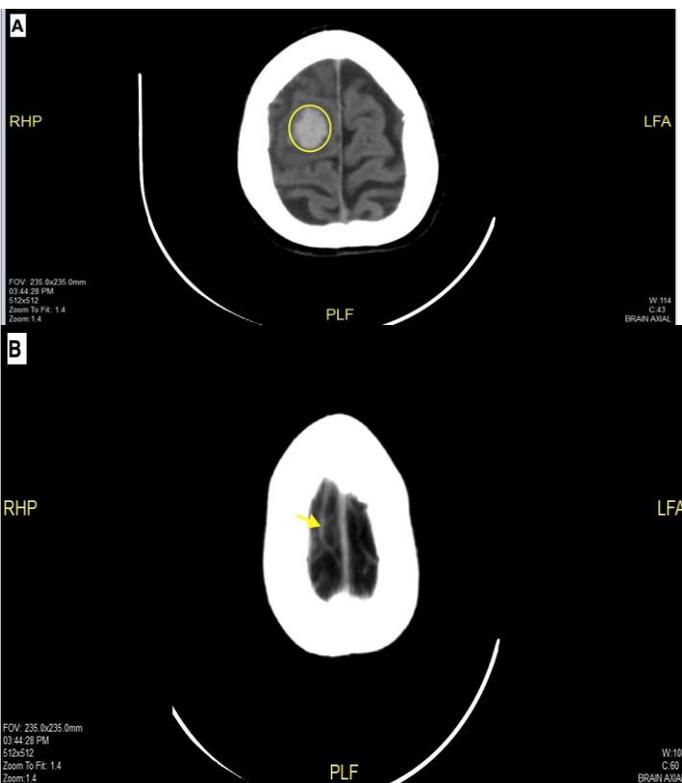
A: Axial CT Brain showing right frontal hemorrhage (Circle). B: An axial CT brain showing cord sign on the right side (arrow). C: Sagittal view of CT brain showing subcortical frontal hematoma (Circle), with thrombus seen at superior sagittal sinus (arrow).
